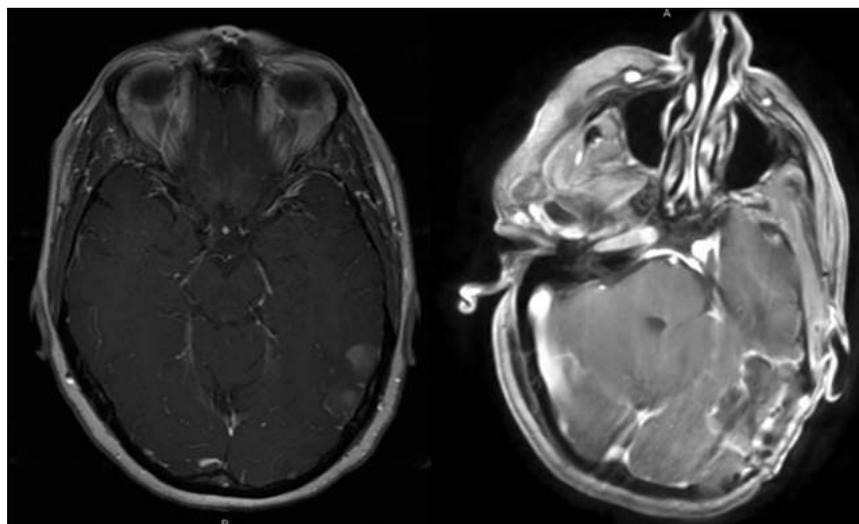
Preoperative and intraoperative axial T1-weighted post contrast images showing complete resection of a posterior left temporal lesion that was removed using an awake mapping technique in the intraoperative MRI.
